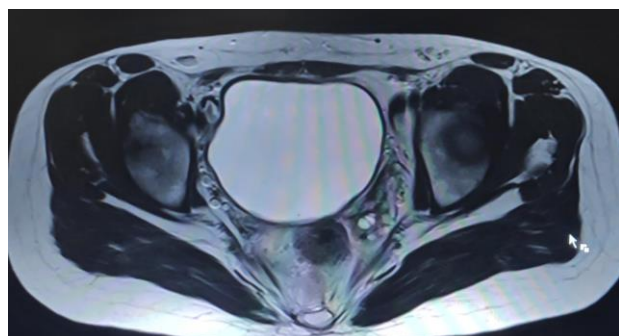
Axial MRI pelvis (T2 weighted sequence) showing normal bilateral ovaries.
